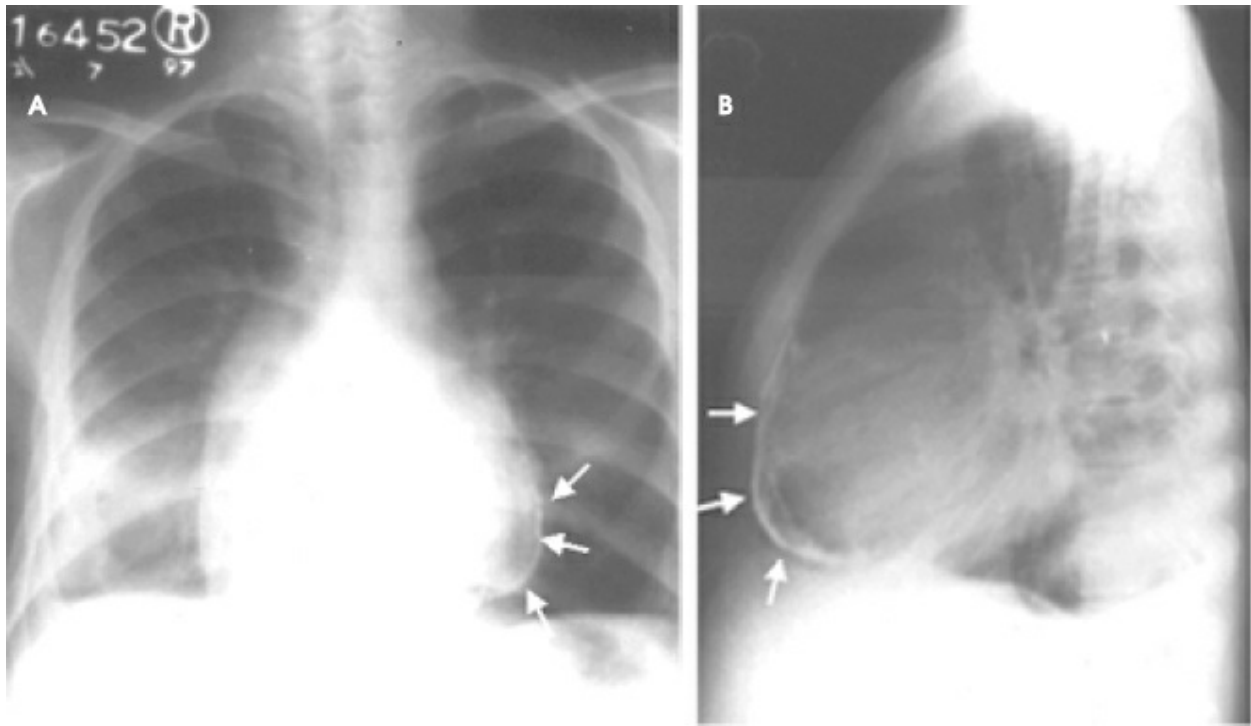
Postero-anterior (A) and lateral (B) chest radiographs showing extensive pericardial calcification in a patient with constrictive pericarditis (arrows).
